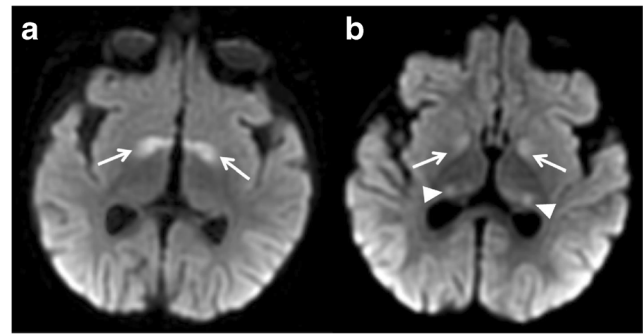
Vigabatrin intoxication in a 6-month-old old patient. Bilateral pallidal (a, b, arrows) and thalamic (b, arrowheads) abnormalities are noted on DWI and confirmed by ADC map (not shown)
